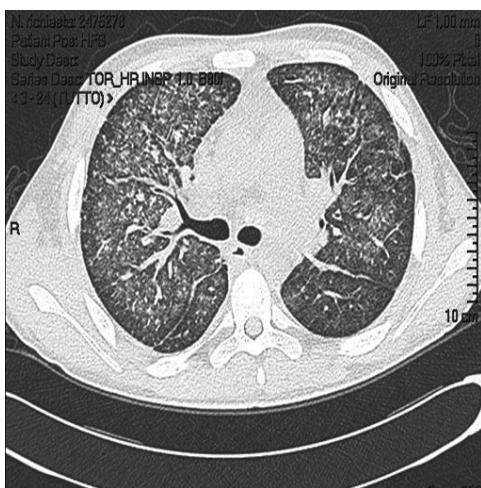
Figure Computed tomography scan showing interstitial thickening concomitant with bronchoalveolar lavage diagnosis of haemorrhagic alveolitis.
